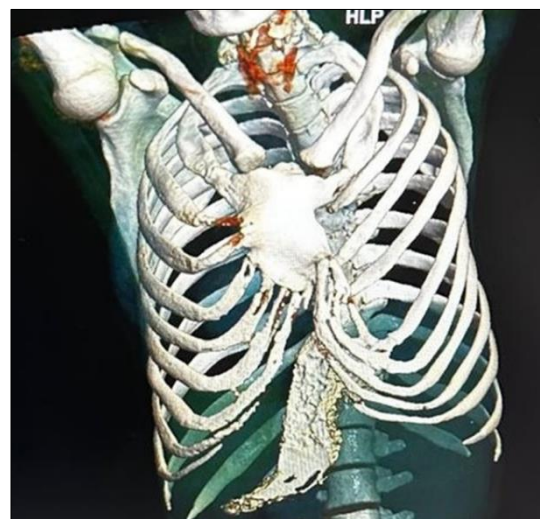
(Non-contrast CT SCAN (coronal view) thorax CT demonstrating a deformed sternum and fused fifth to ninth ribs)
